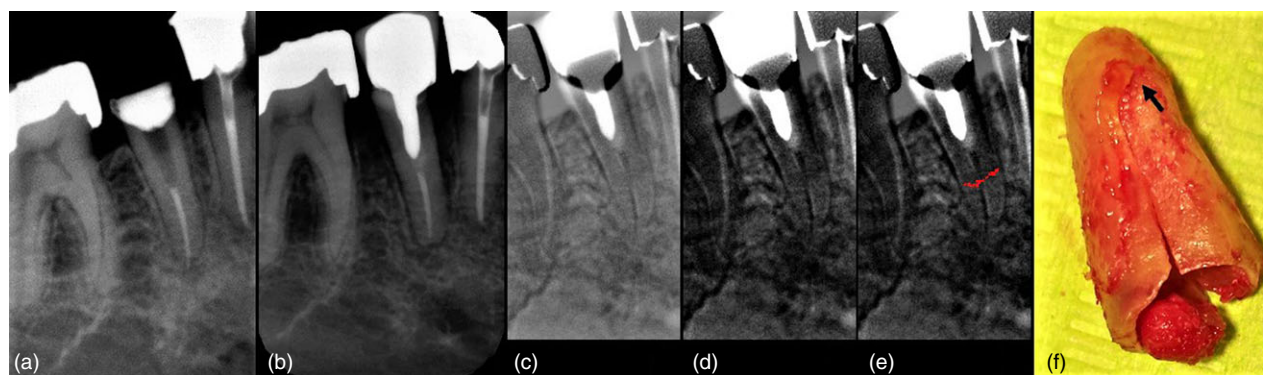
(a) Post-operative radiograph. (b) After 12 years: 'J-shaped' radiolucency in the mesial area as well as a radiolucent area at the apical third of the root. No evidence of a VRF (c) Result of digital subtraction of b from a: a dark horizontal line in the body of the root can be distinguished at its apical part. (d) DSI processed using CET. (e) Image d processed using PCT. (f) VRF was confirmed after the extraction of the tooth. The arrow indicates the horizontal part of the VRF corresponding to the line visualised with the DSR and pseudocoloring.
